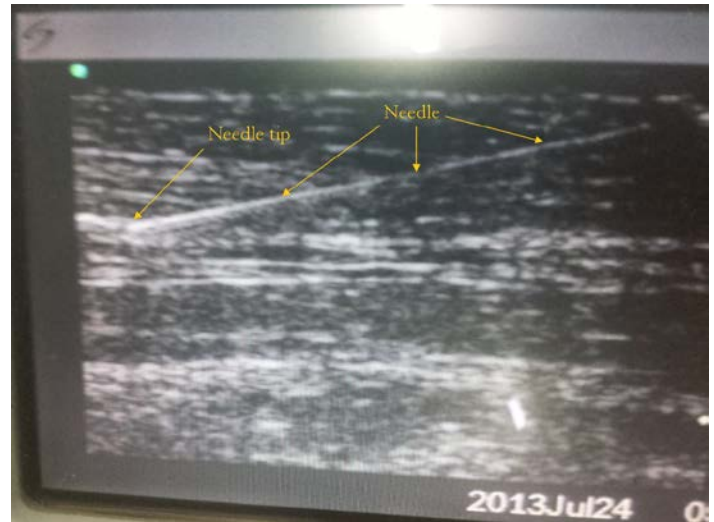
In-plane ultrasound image of needle.
